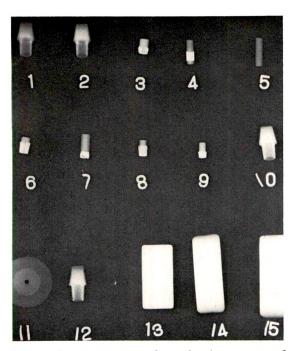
Roentgenogram of 15 abrasive erasers of widely varying composition and representing the products of 10 different manufacturers.
